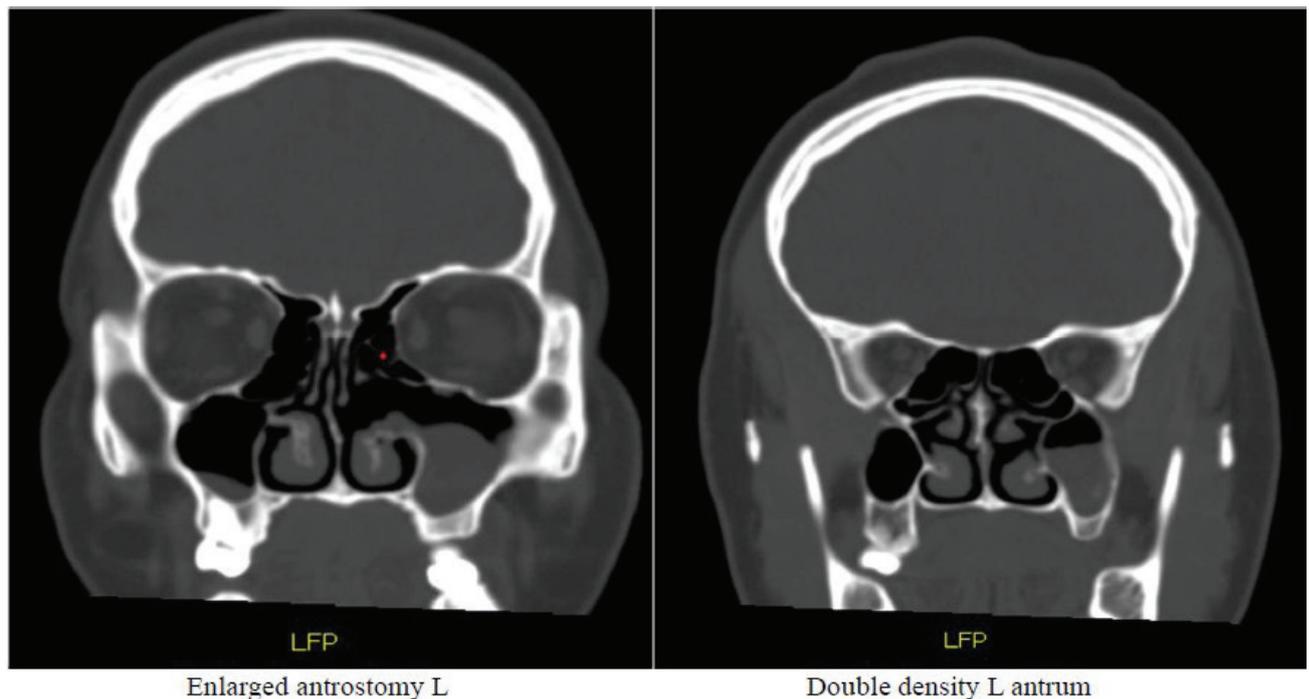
CT scan shows an expanded left maxillary sinus ostium and the presence of double densities in the left enlarged maxillary sinus.
